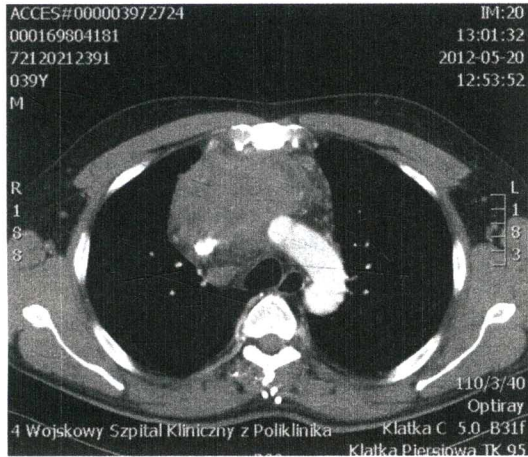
CT scan showing a large tumor in the anterior mediastinum, which is invading the posterior wall of the sternum and aortic arch, compressing the right and left lung parenchyma, and constricting the trachea
